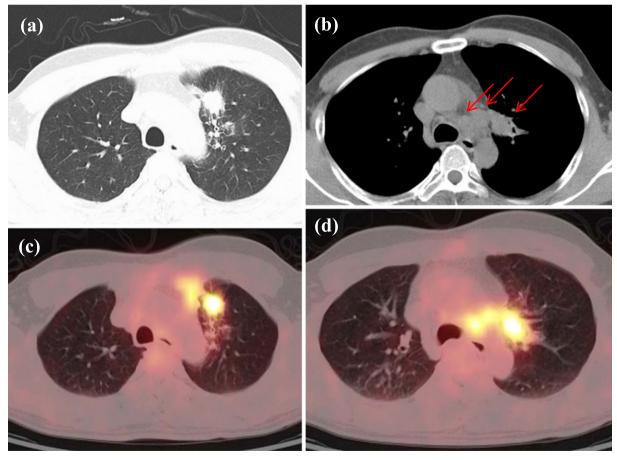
a, b: Chest computed tomography showing a nodule measuring 22×21 mm in left S³, as well as #4L, #5 and #11L lymphadenopathy (arrows). c, d: A PET/CT scan showing an avid FDG uptake in the nodule (c) with lymphadenopathy (d).
